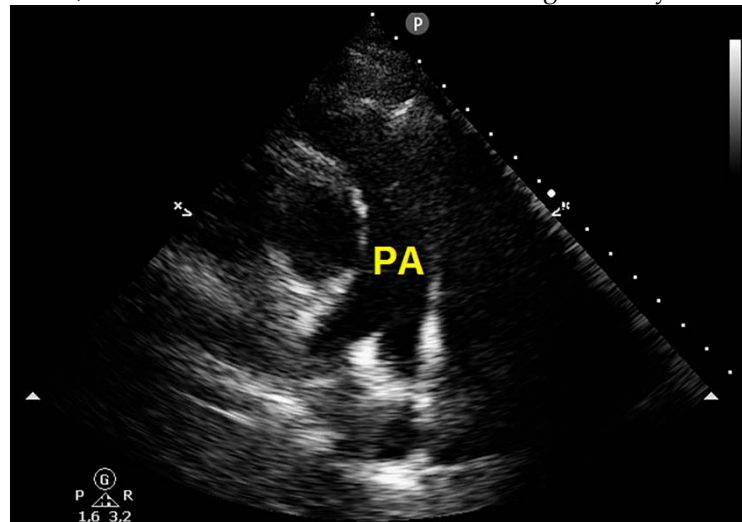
Basal short-axis view from transthoracic echocardiography, demonstrating total regression of mobile saddle thrombus after thrombolytic treatment. PA, pulmonary artery.
